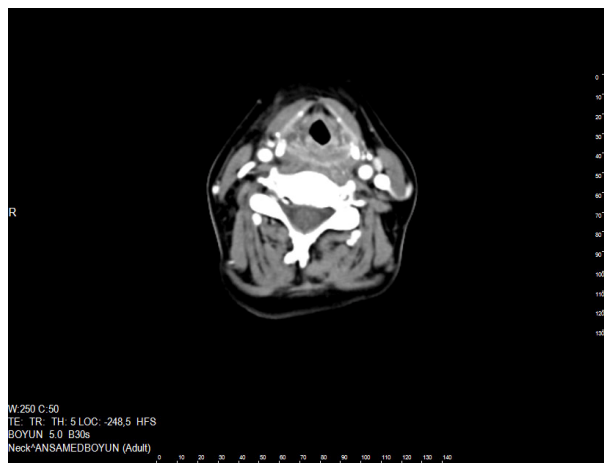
Neck MRI after Radiotherapy
